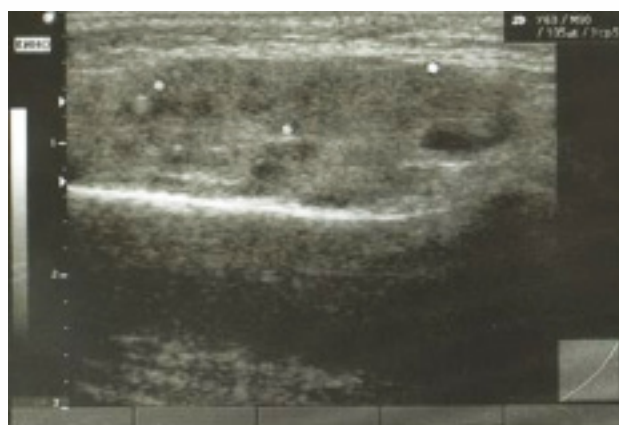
Ultrasound image of the left parotid gland of 12 year-old patient M., medical history No 243.
